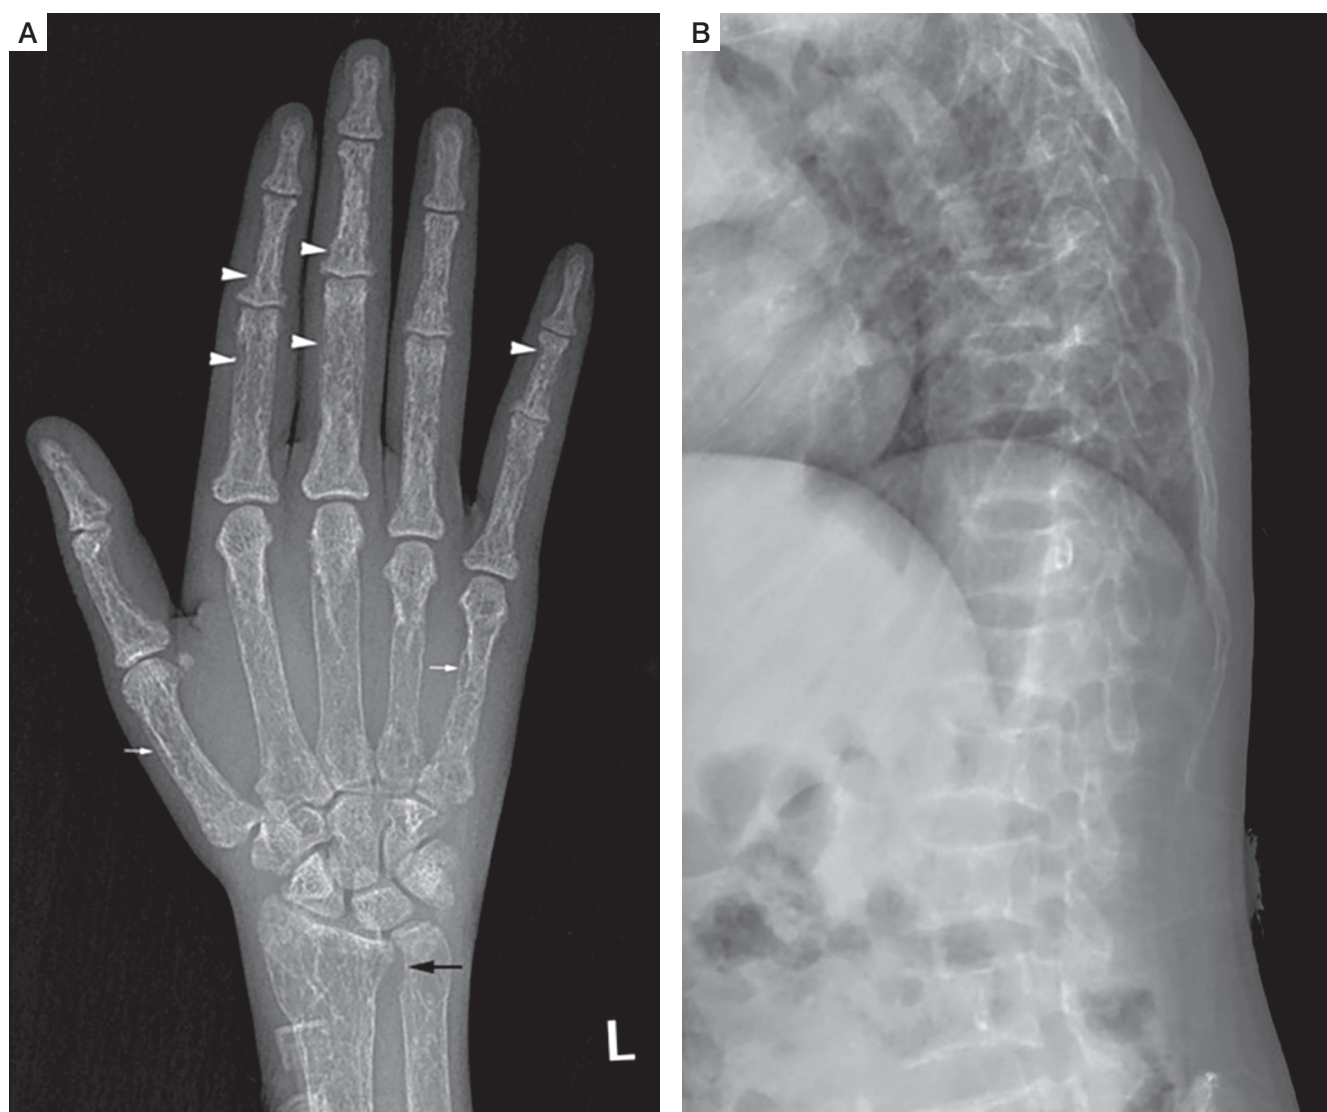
Skeletal survey: Diffuse osteopenia with coarse trabecular pattern seen. Anteroposterior radiograph of the left hand (A) shows subperiosteal resorption, predominantly along radial aspect of proximal and middle phalanx of 2nd and 3rd finger (white arrowheads), cigar/oval shaped intracortical resorption (white arrows), and subchondral resorption at ulnar side of distal radioulnar joint (black arrow). Lateral radiograph of spine (B) shows biconcave/crush fracture of multiple vertebral bodies with thoracic kyphosis.
